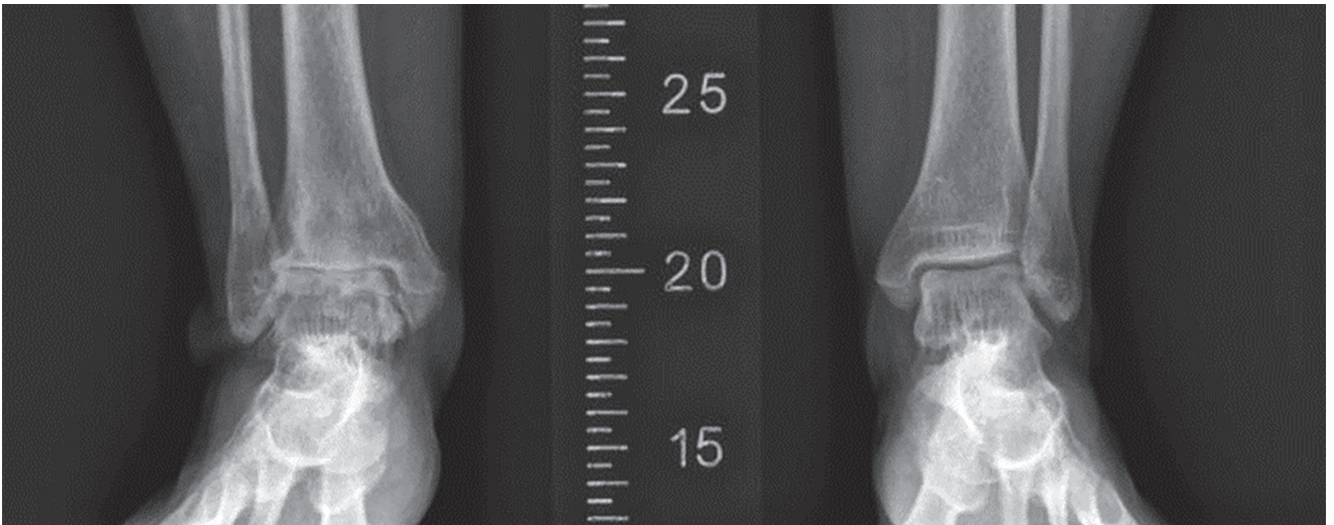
Radiographs showing the asymmetry of the tibiotarsal joints and degenerative osteoarthritis in the right joint.
